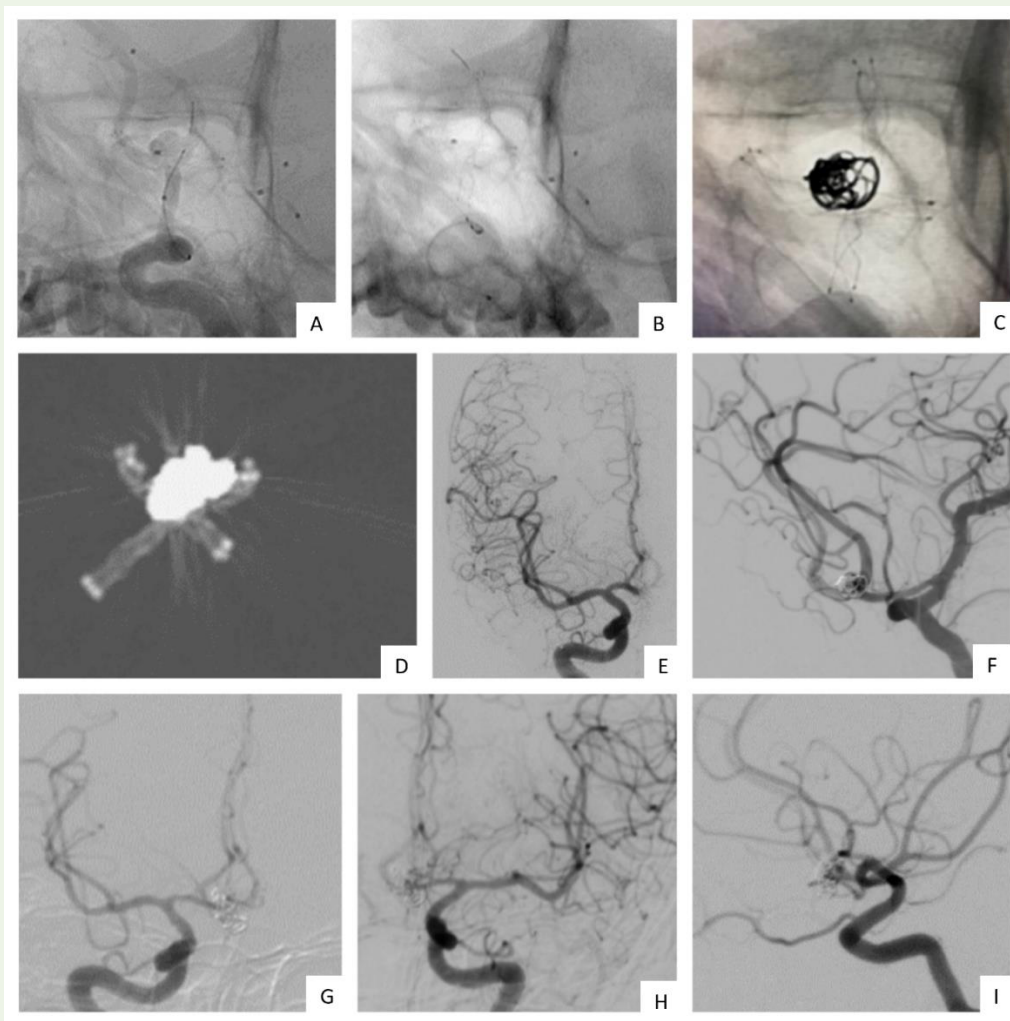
Internal carotid angiogram in anteroposterior view shows deployment of stent from right A2 segment to left anterior cerebral artery (Figure 2A). The second stent was deployed from left A2 segment to right anterior cerebral artery with jailing of microcatheter (Figure 2B). Subsequently, coiling was performed via jailed microcatheter. Figure 2C depicts coils within the aneurysm. (Figure 2D) is a reconstructed CT image showing X configuration of the stents and coils within the aneurysm. Final right (Figure 2E) and left (Figure 2F) internal carotid artery angiograms show good reconstruction of the anterior communicating artery complex and bilateral A2 segments, along with a small residual filling of the inferior portion of the sac. Control angiography done after 6 months (Figure 2G) – Right ICA angiogram, (Figure 2H) – Left ICA angiogram) shows complete exclusion of aneurysm from circulation.
